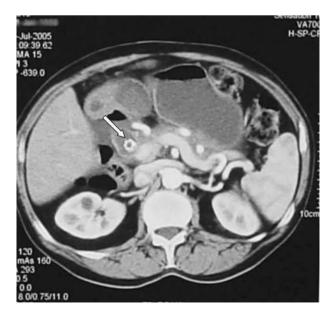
CT showing the presence of the metallic stent (arrow).
